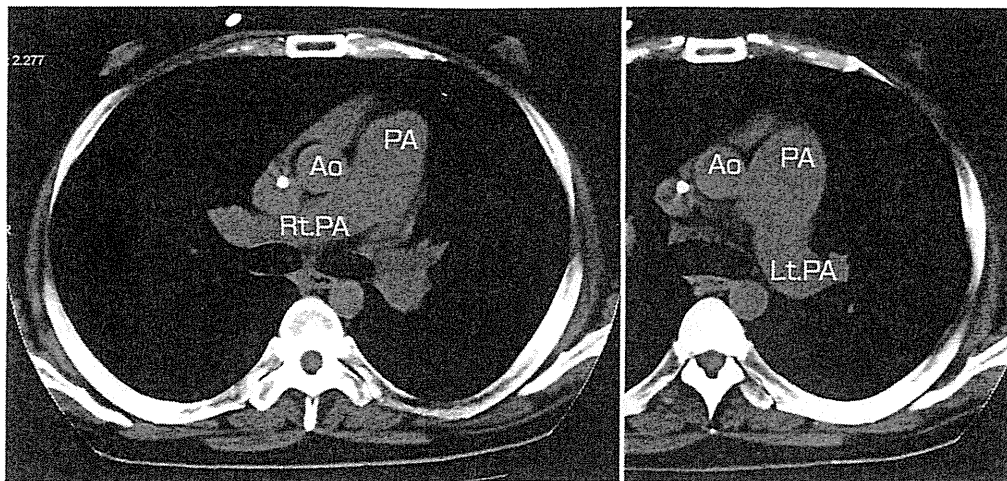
PVOD 症例の単純 CT 像 (縦隔条件)
